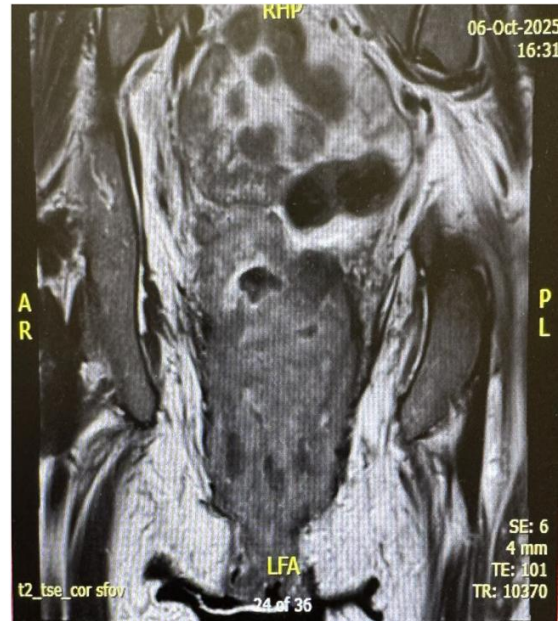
MRI coronal view showing extensive abnormal soft tissue.
